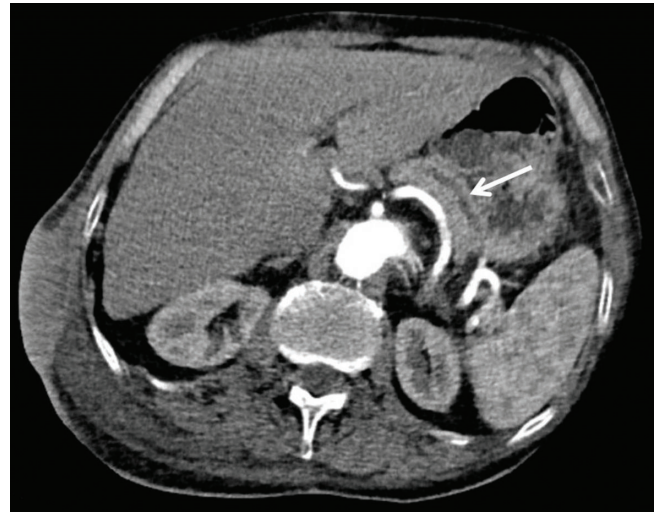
CT image demonstrating a slightly stretched pancreas with dilated pancreatic duct to 4 mm (arrow) and upper portions of the underlying partial thrombosed abdominal aortic aneurysm extending distally from the origin of the superior mesenteric artery (SMA) to the bifurcation with an external diameter of 79 mm × 59 mm
